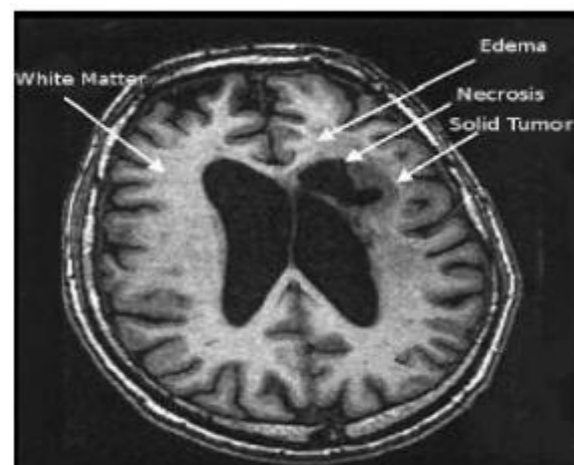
One axial slice of a MR image of the brain showing tumor areas
